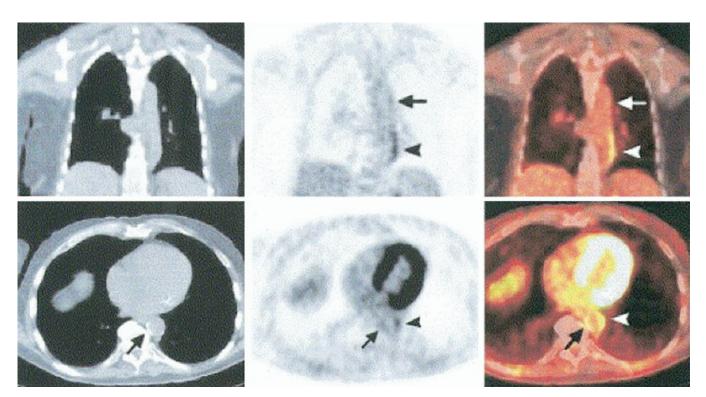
Visualization of aortic atheroma on PET/CT. PET and CT images acquired after administration of FDG in patients with aortic atheroma. Top row: coronal CT (left), FDG-PET (middle), and fused PET/CT images (right). There is no calcium present in the aortic wall on CT. On PET and fused images, mild (arrows) and moderate (arrowheads) grades of FDG uptake are seen in the aortic wall. Bottom row: axial CT (left), FDG-PET (middle), and fused PET/CT images (right). CT image shows calcification on the right side of the descending aortic wall (arrows), which on PET and fused images demonstrate mild (arrows) uptake indicating mild inflammation. Higher level FDG activity is also seen on the left side of the descending aortic wall (arrowheads) indicating a higher level of inflammation in this segment of noncalcified vessel wall. (Reprinted with permission.⁹³)
